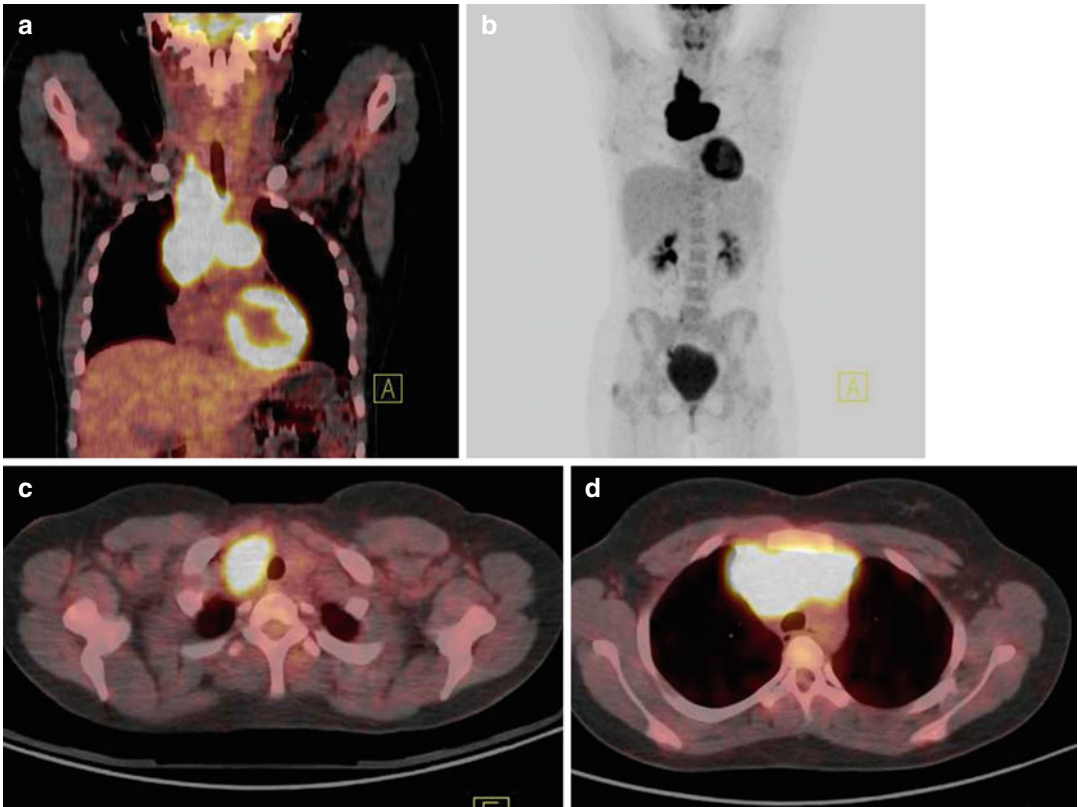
Coronal PET/CT image (a), MIP image (b) and axial PET/CT images (c, d) show a large hypermetabolic lymphatic mass extending from the right supraclavicular area to the anterior mediastinum (SUV_{max} 16.4)
